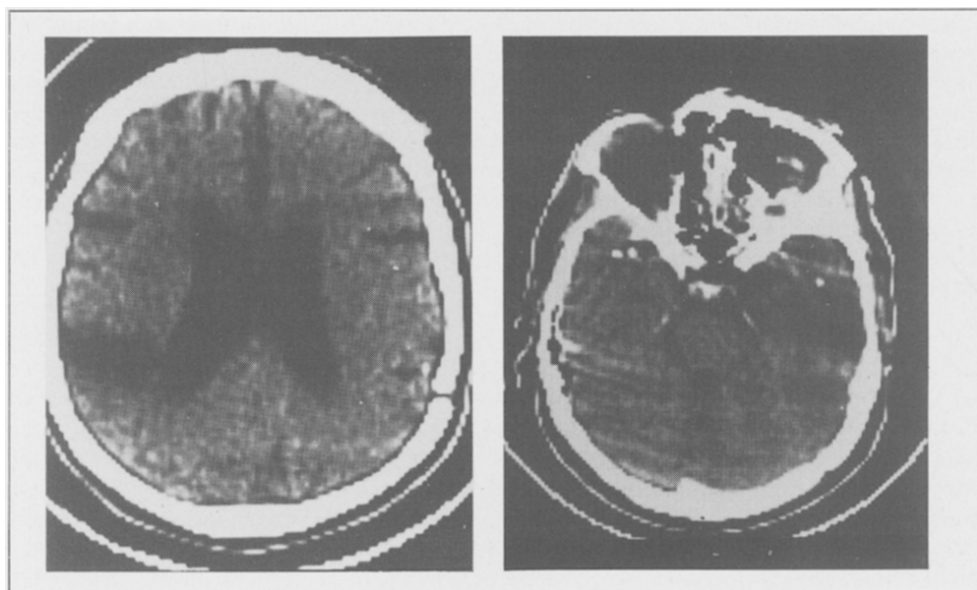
CT scans of Case 1 reveal a right-sided temporal lesion (left image) and left-sided temporo-parietal lesion (right image).
